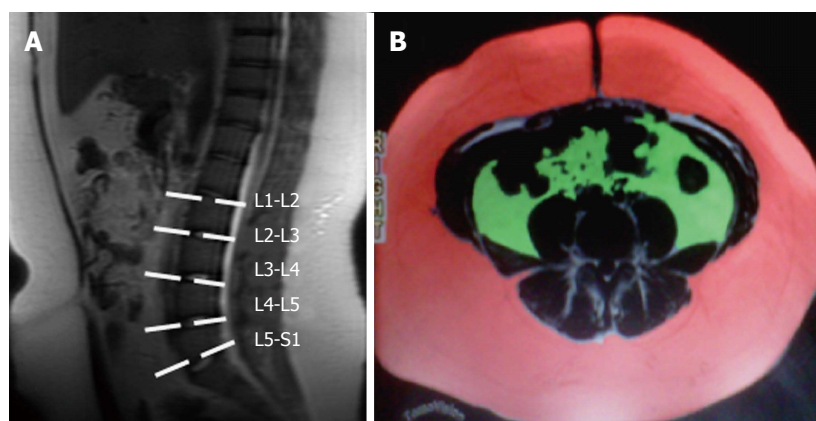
Subcutaneous and visceral fat measurement technique. A: Sagittal T1-weighted localizer MR image used to select levels for analysis (L1-L2, L2-L3, L3-L4, L4-L5, L5-S1); B: Axial T1-weighted MR image with water suppression at the L4-L5 level. Contrast was manually adjusted to select signal from subcutaneous (red) and visceral (green) adipose tissue. Area of this fat was calculated by the workstation and summarized with that of other levels.
